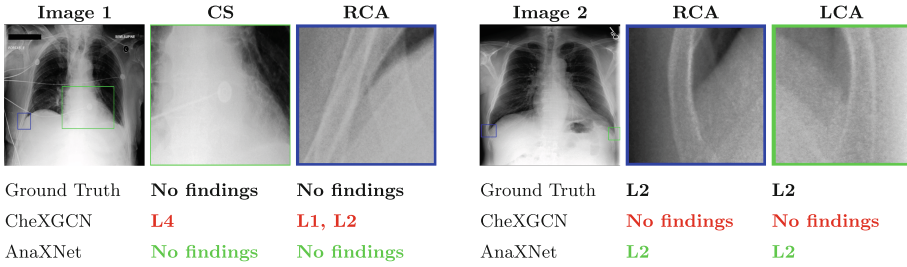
Examples of the results obtained by our best two models. The overall chest X-ray image is shown alongside two anatomical regions. The predictions from best performing models are compared against the ground-truth labels.
